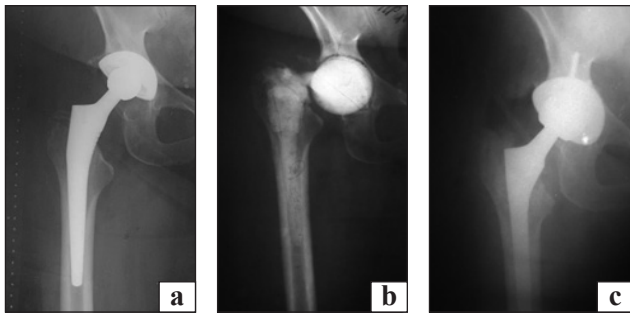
Patient L. Radiographs "before" and "after" surgical interventions: periprosthetic infection of the right hip joint (a); condition after revision, installation of a cement spacer (b); after revision arthroplasty (c)
